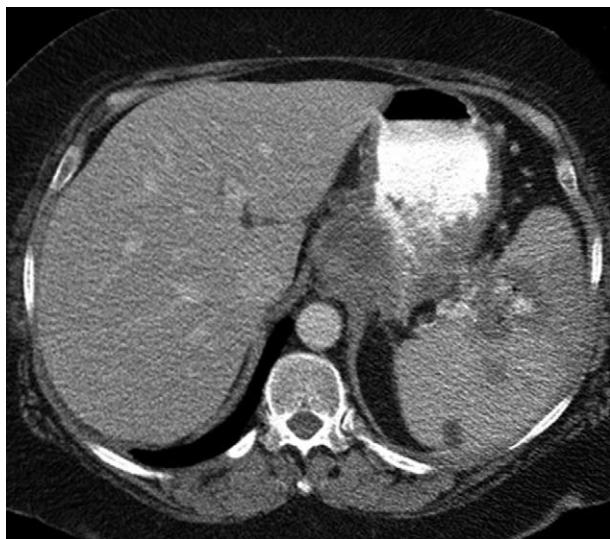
Axial CT showing low density lesions in the spleen which are possible metastasis.
